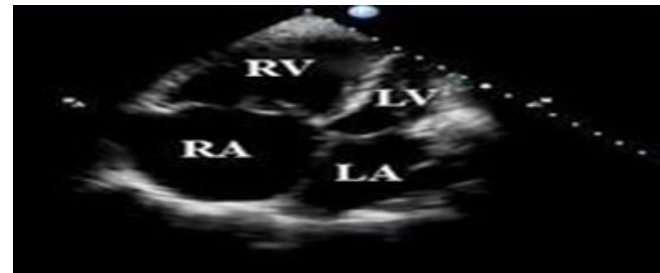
Echocardiogram showing Dilated RV.
